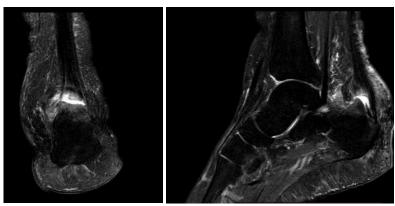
MRI left ankle (sagittal and coronal), in STIR sequence: DP FS hyper-signal of distal Achilles tendon with discontinuity and pre-achilles bursitis (arrow)
